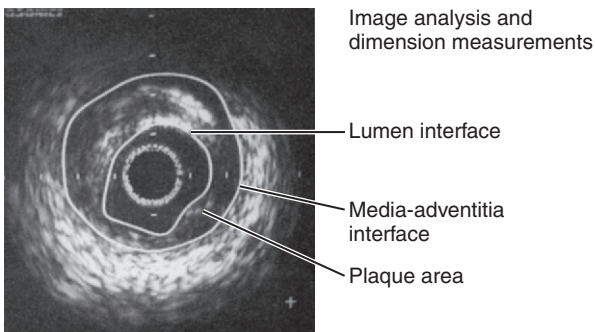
Intravascular ultrasound (IVUS) images showing how ultrasound-derived measurements are obtained from planimetry of the lumen and media-adventitia interfaces. *Halo* is the term given for lucency around the central black space of the IVUS catheter. (Courtesy of John M. Hodgson, MD.).
